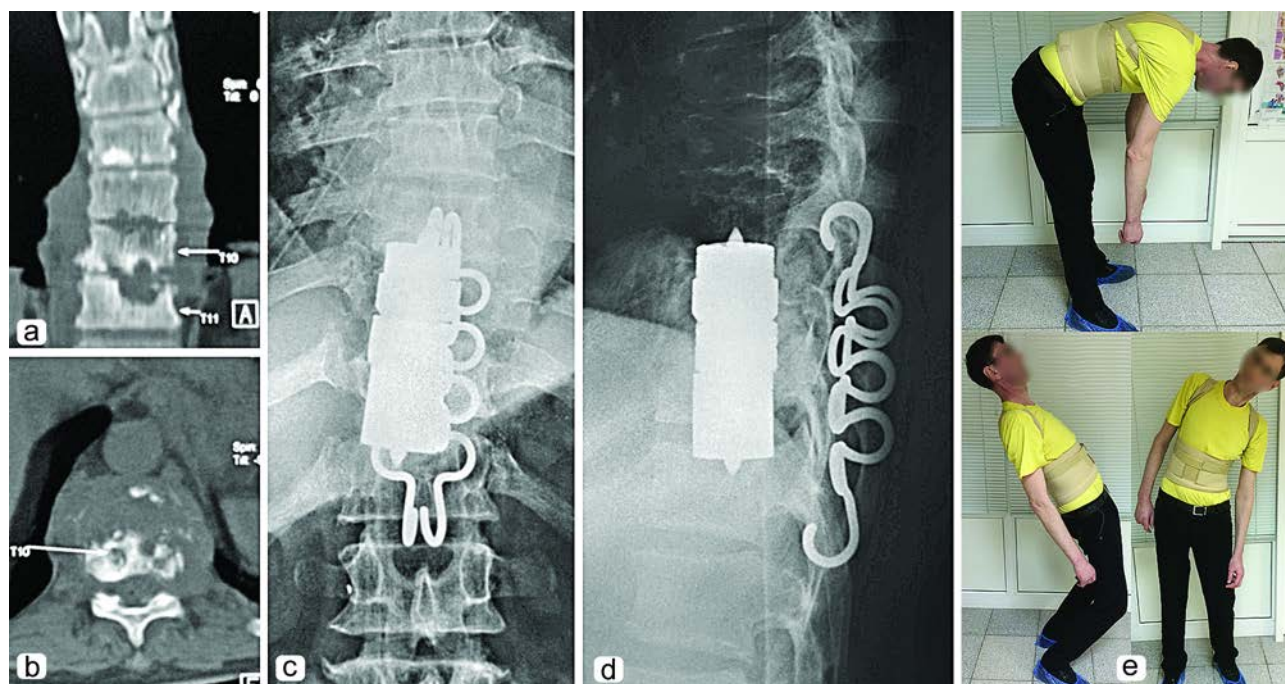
A 32-year-old patient G. with progressing tuberculous spondylitis of Th₉-Th₁₂ vertebrae: (a, b), preoperative CT scan; (c, d), AP and lateral spondylograms 3 months after combined spondylodesis; (e), functional result 6 months after surgical treatment
